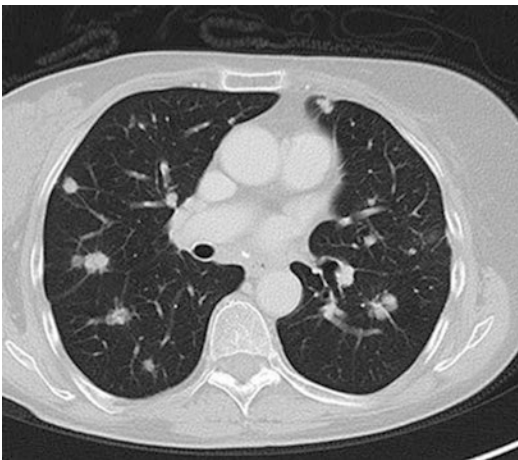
CT of the chest: multiple ill-defined nodular lesions at both lungs in metastatic melanoma
